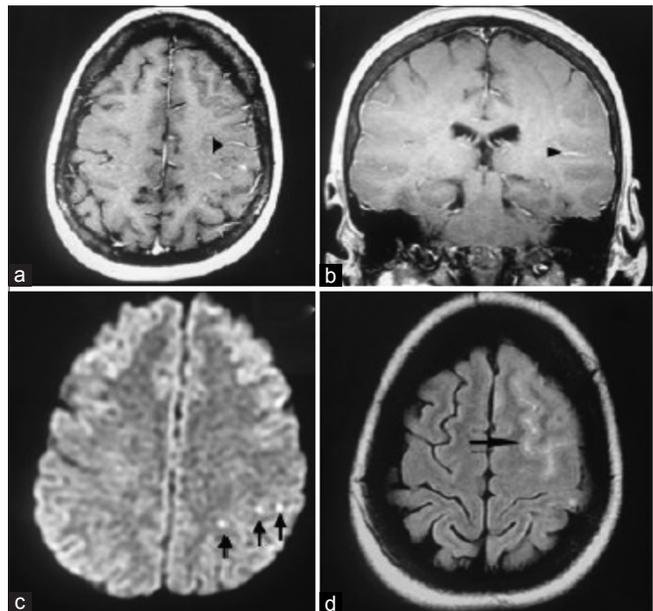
Magnetic resonance imaging of the brain demonstrating small infarctions and prominent leptomeningeal collaterals. Gadolinium-DTPA-enhanced T1 images (axial, a and coronal b) and axial fluid attenuation inversion recovery (large arrow in d) demonstrating pial enhancement (arrowheads in a and b) consistent with previously demonstrated leptomeningeal collaterals on angiography. The diffusion-weighted image in c (small arrows) demonstrates three small acute-early subacute infarcts in the right high parietal region
